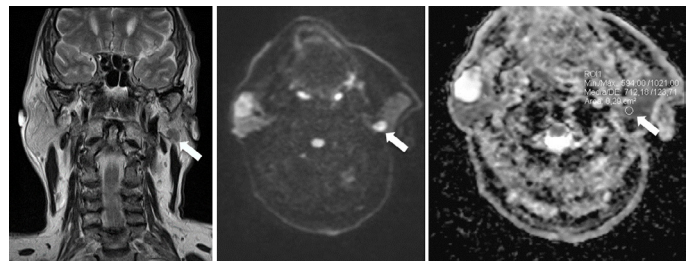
Warthin tumour (lymphomatous adenoma) in the left parotid gland. A. A smoothly marginated mass, low to intermediate signal in coronal T2-WI MR. B. It is hyperintense on DWI (b 1000 sec/mm<sup>2</sup>) (arrow). C. On ADC map it shows low signal intensity ( $0.71 \times 10^{-3} \text{ mm}^2/\text{sec}$ ) (arrow), compatible with restricted diffusion. See the difference with the contralateral tumor in the right parotid gland, which was a benign mixed tumour (BMT).
